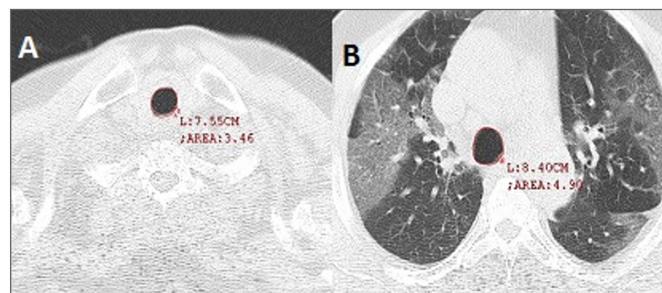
Axial thorax CT images of the measurements made from level 1 (A) and bifurcation superior (B) (mean tracheal air column area= (3.46+4.90)/2: 4.18 cm²).
